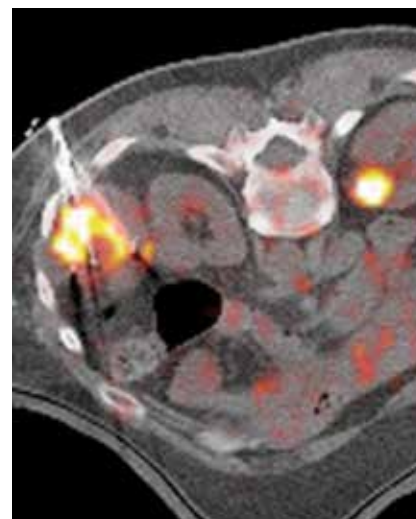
Fused PET/CT image demonstrates inferior cryoablation probes placed within the tumor mass.
